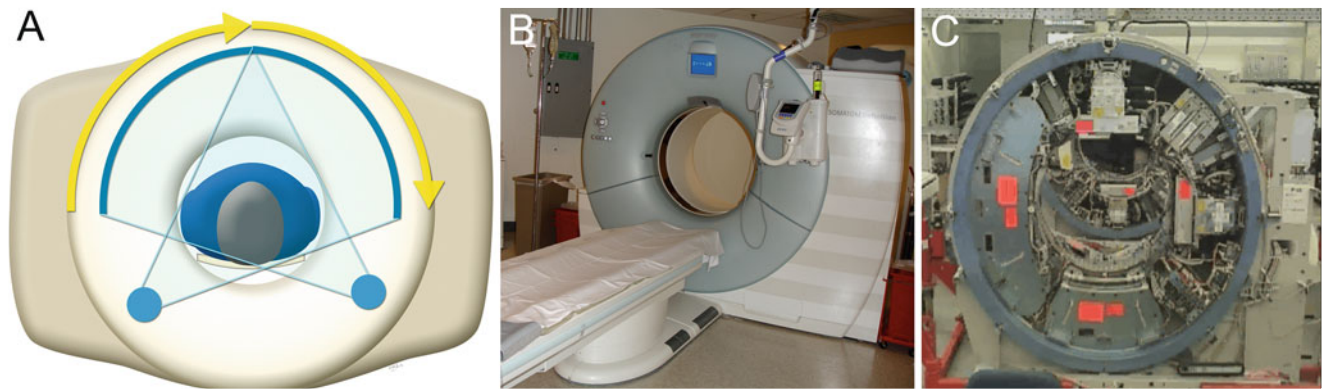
(a) Dual-source computed tomography with a gantry that houses two X-ray tubes and detector arrays that are aligned 90° from each other. (b) External view of a dual-source computed tomography
